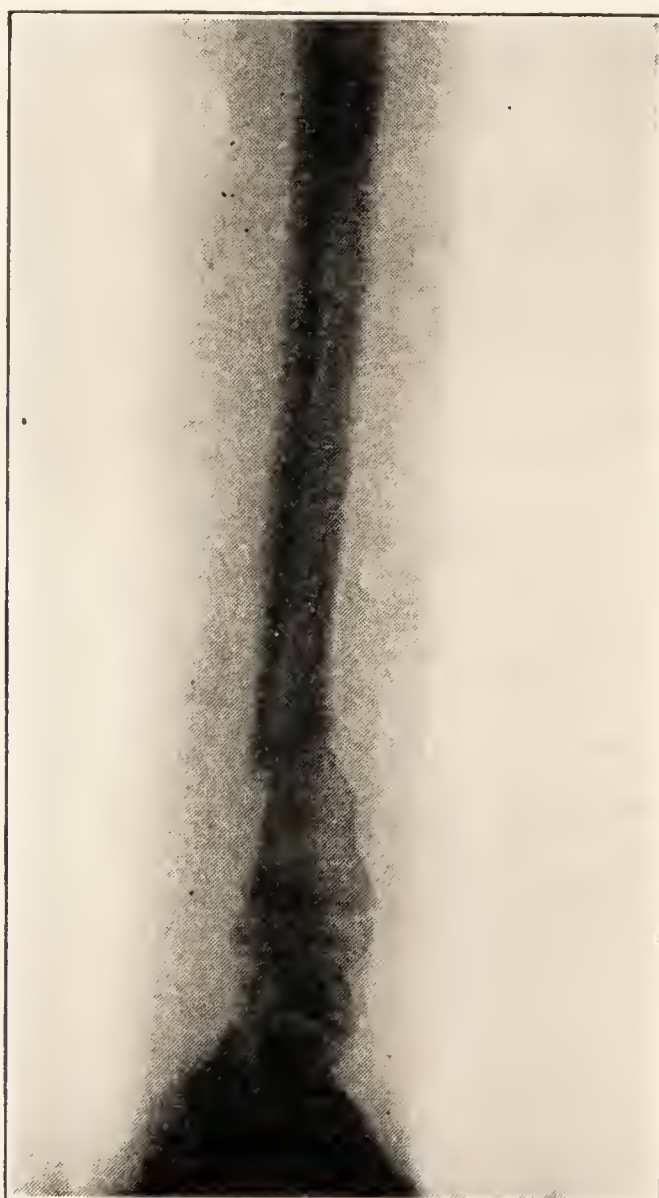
X-ray picture showing fracture of ulna (side view).
